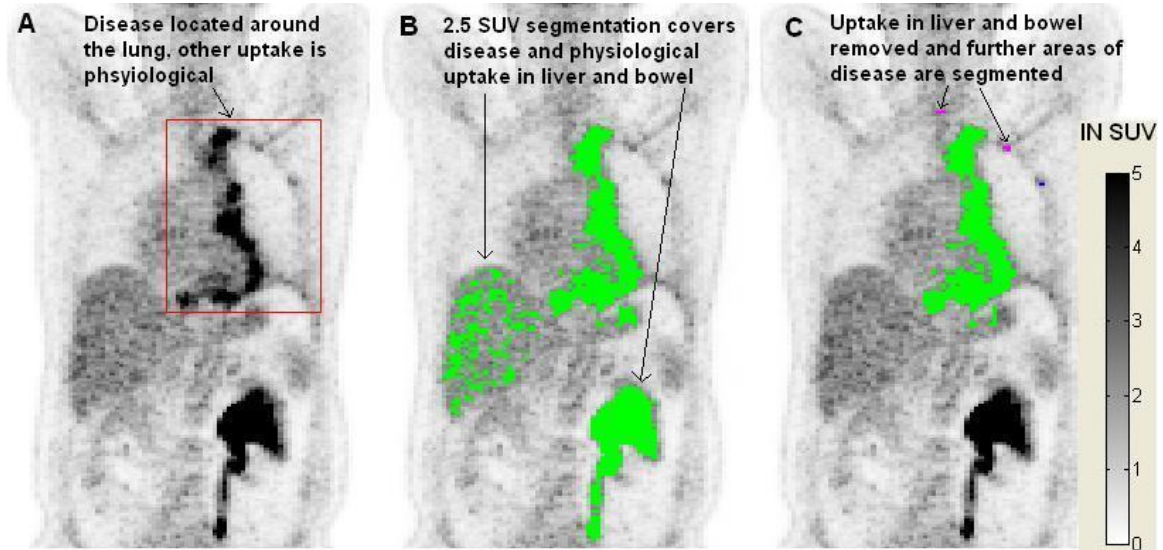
Removed Areas of Physiological Uptake for 2.5 SUV Segmentation
